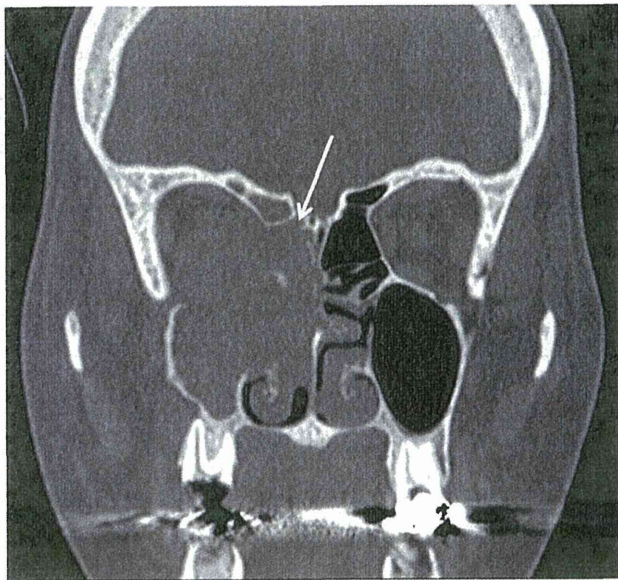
CT scan of head obtained upon admission. The tumor occupies the right nasal cavity and maxillary and ethmoidal sinus, involving the ethmoid bone (arrow).
